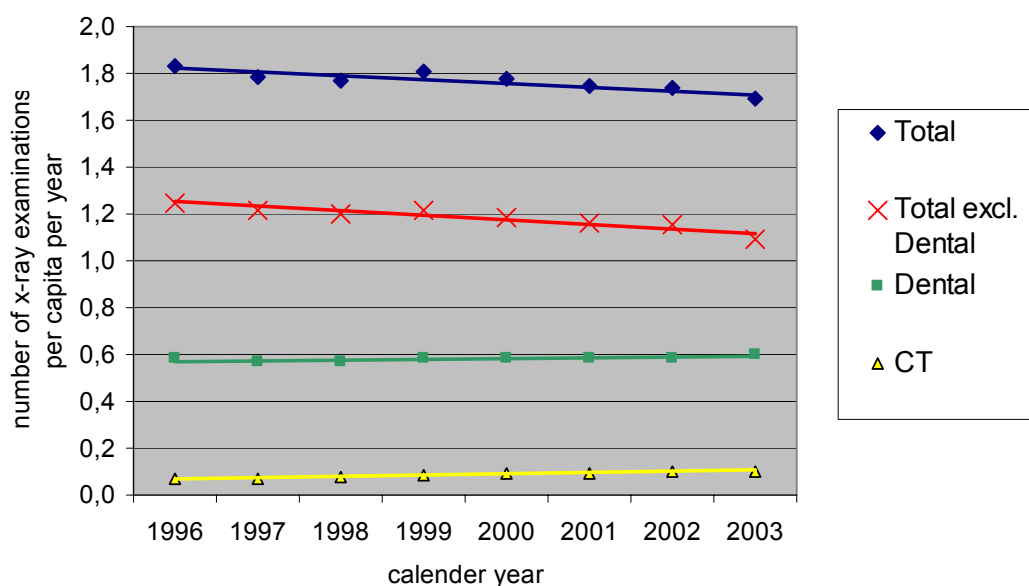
Annual number of medical and dental x-ray examinations per capita in Germany for 1996 to 2003
